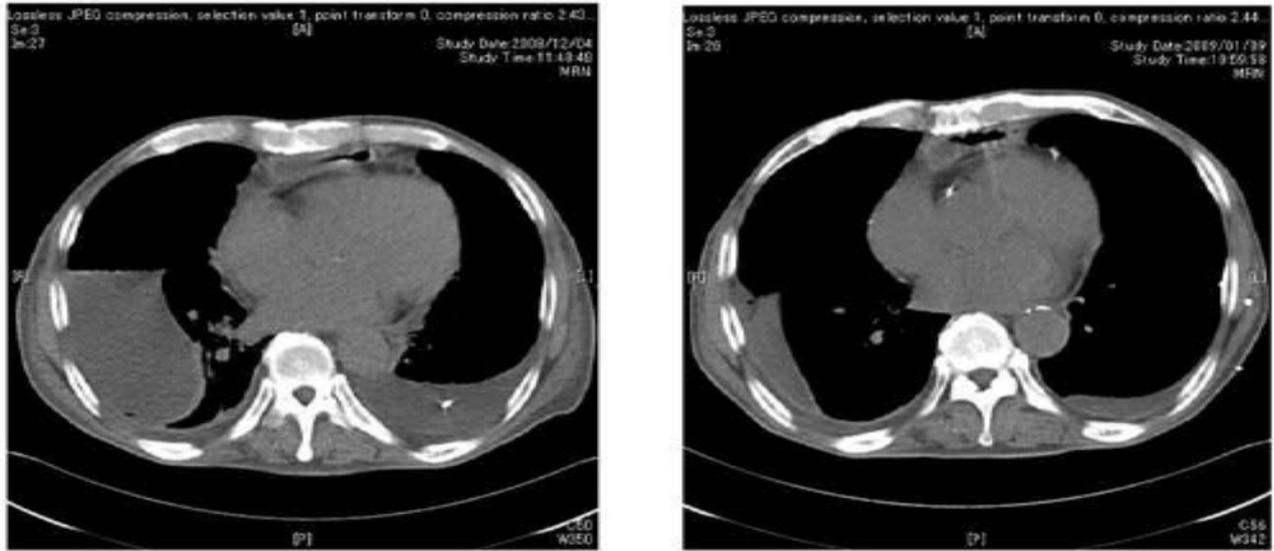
Computed tomography of thorax; (Left) before lipiodol lymphangiography, bilateral chylothorax are revealed; (Right) after lipiodol lymphangiography, chylothorax improved.
